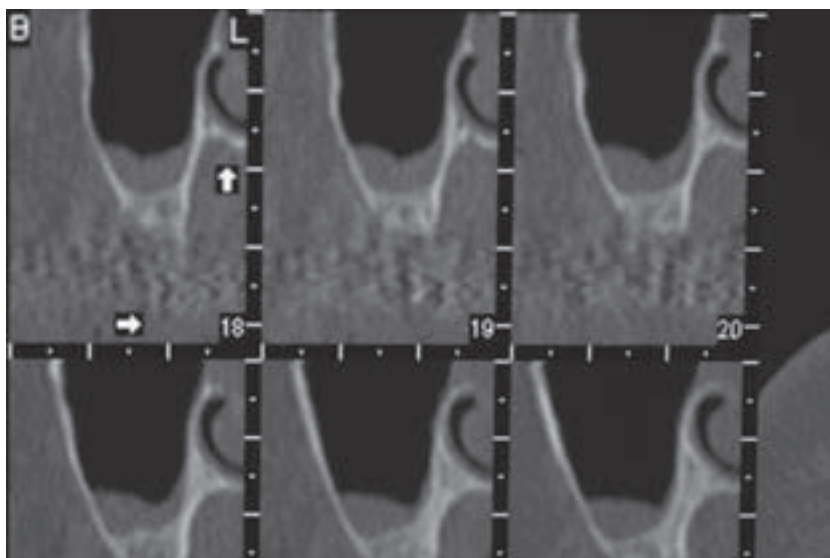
CT scan 2 months after Augmentin/ prednisone therapy.
